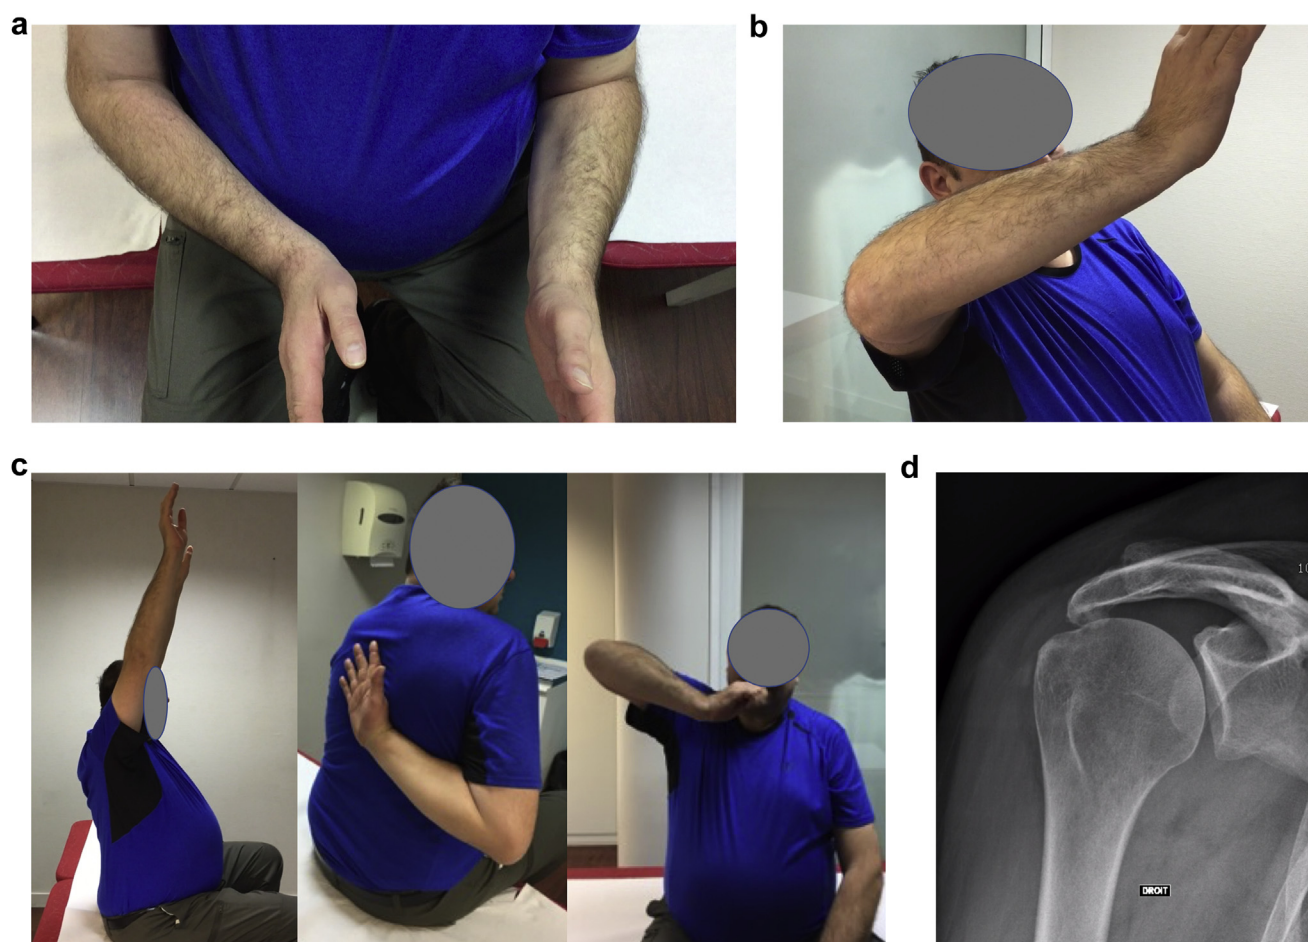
Preoperative clinical and radiographic presentation. Male, 52-year-old, right nondominant side. (a) Negative external rotation with elbow at the side (ER1). (b) Limited external rotation in abduction (ER2). (c) Normal active forward elevation and internal rotation. Positive hornblower sign. (d) Anteroposterior view. Hamada stage 2.
